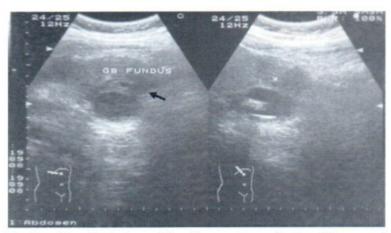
Chronic cholecystitis with acute exacerbation. Ultrasound demonstrates contracted gallbladder with gallstone. The gallbladder wall is thickened with anechoic zone in the wall (blackarrow).
